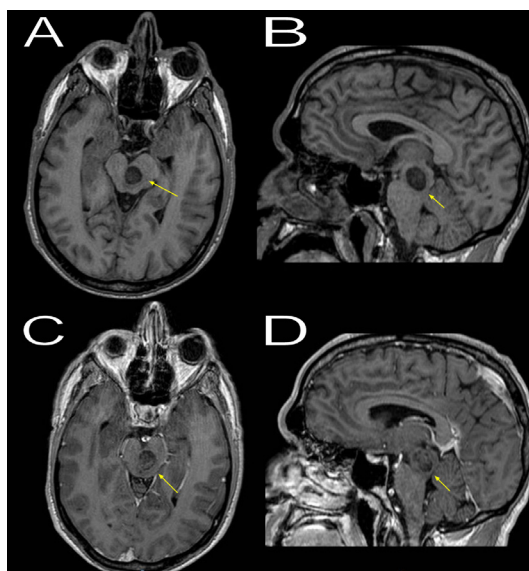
Brain MRI (left: axial, right: sagittal). T1-weighted images without contrast (A,B) and T1-weighted images with contrast (C,D) show a well-defined lesion with mild contrast enhancement at the left midbrain tegmental region (yellow arrow), measuring 1.5 cm anteroposterior × 1.3 cm transverse × 1.9 cm craniocaudal.
